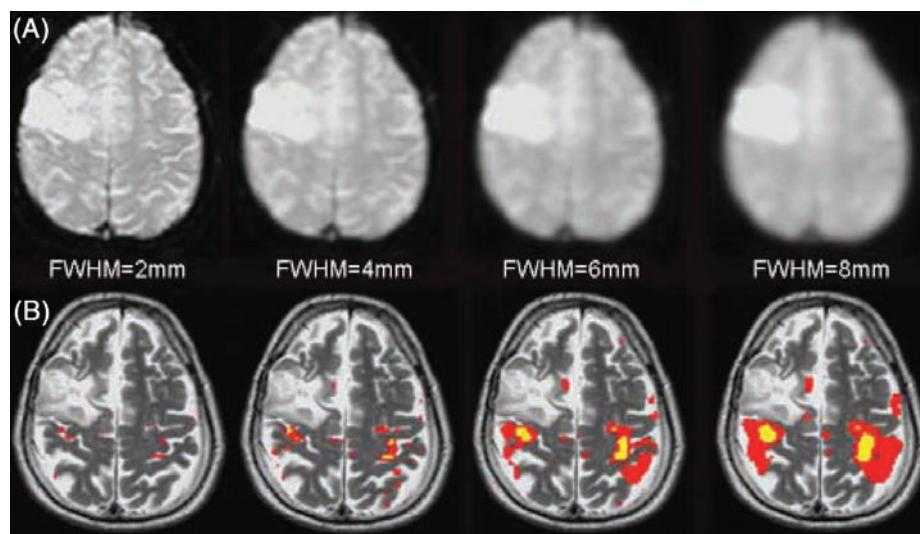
The effect of smoothing on BOLD activity. Top images (A) show the effect of smoothing on T2* image, which increases blurring. The data was acquired using 1.5 T (TR = 4 seconds, TE = 60 seconds, matrix = 128 × 128, FOV = 240 mm). Bottom images (B) show functional activity obtained during bilateral finger tapping and overlaid onto the anatomical T2-weighted images. Spatial smoothing blurs the sharp edges, causing reduced spatial resolution that tends to spread out the activation and eventually decrease the BOLD signal magnitude. Abbreviation: BOLD, blood oxygenation level dependent.
